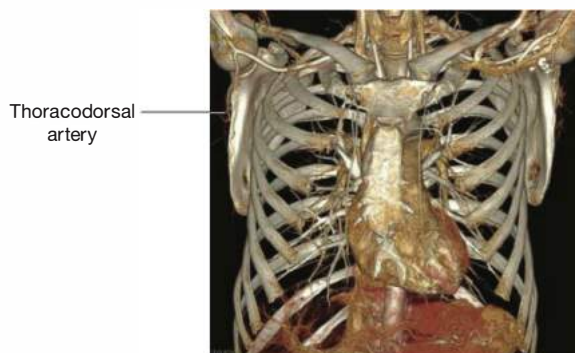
• Preoperative CT angiography of the thoracodorsal vessels.
